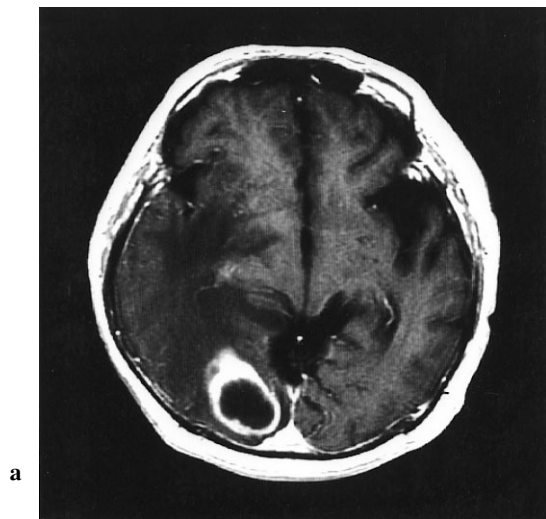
a: There was an intensely contrasted area in the right occipital lobe using CE-MRI (TR: 500, TE: 11). b: In Tc SPECT of occipital tumor, there was no accumulation of Tc in the lesion corresponding to necrosis in CE-MRI. c: In TI SPECT of parietal tumor, doughnut-shaped TI uptake, which had no accumulation in the site appearing to necrosis in CE-MRI, was disclosed.
